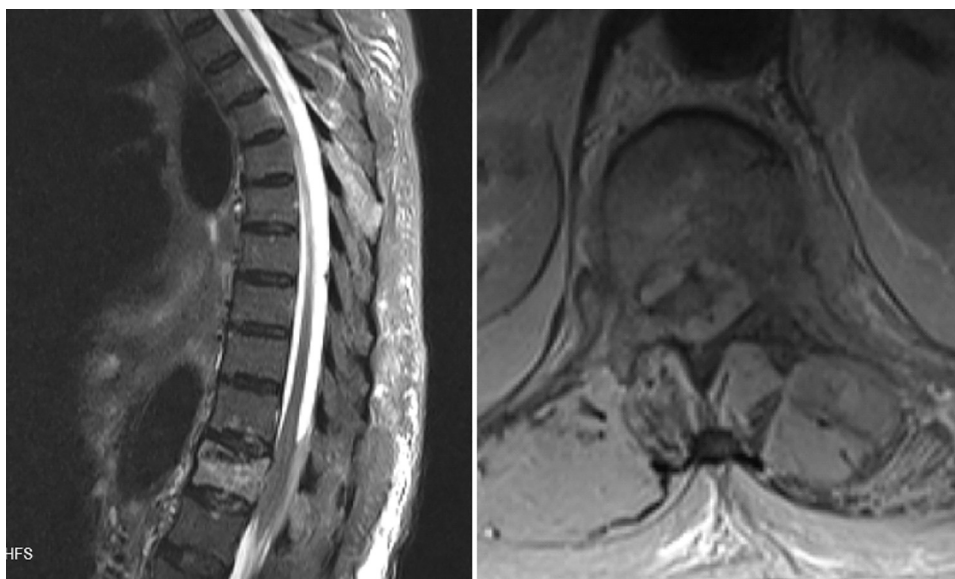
Magnetic resonance imaging (MRI) scan of the thoracolumbar spine showed a high-signal mass including epidural area and left paravertebral area at the level of T12 vertebrae.
